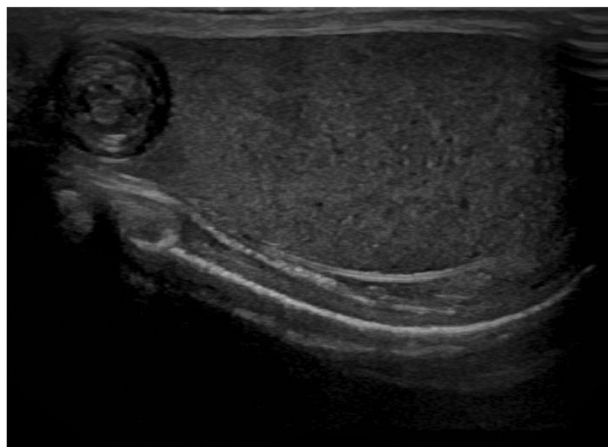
Ultrasound findings of testicular epidermoid cyst.*
